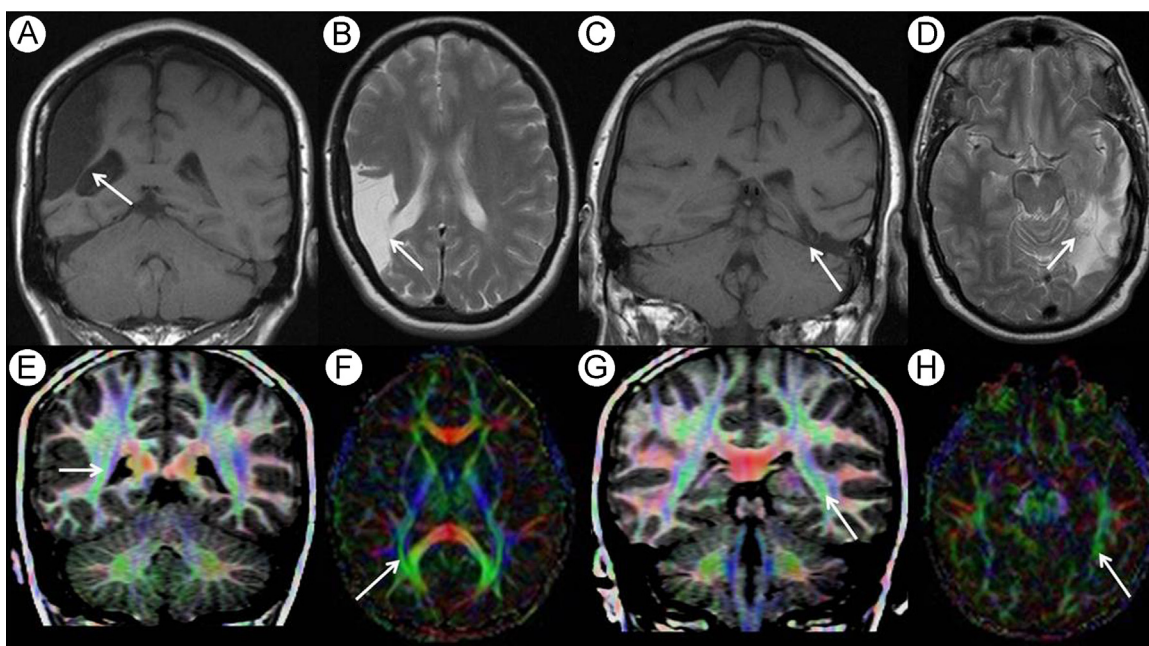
Quadrantanopia in 2 patients. (A) Coronal T1- and (B) axial T2-weighted images in a patient presenting solely with a left inferior quadrantanopia. There is a large, mature right inferior divisional MCA infarct (arrows, A and B). (C) Coronal T1- and (D) axial T2-weighted images in a second patient presenting with a right superior quadrantanopia show a left inferior temporal infarct (arrows, C and D). Fused color FA and T1 volumes (E and G) and axial color FA maps (F and H) showing the correlating normal positions of the optic radiations affected in the cases above. FA, fractional anisotropy; MCA, middle cerebral artery.
